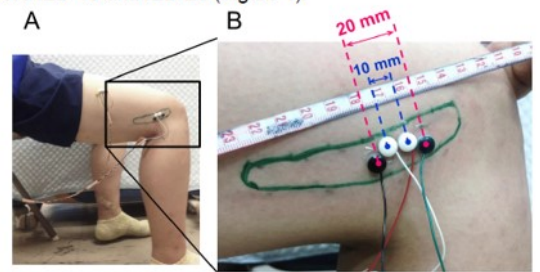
A: The picture of attaching electrode on superficial region of VI for the woman. This picture was taken the lateral side of right leg. B: Green line is superficial region of VI identified by ultrasound. Interval of center to center of white electrodes is 10 mm, and that of black electrodes is 20 mm.
